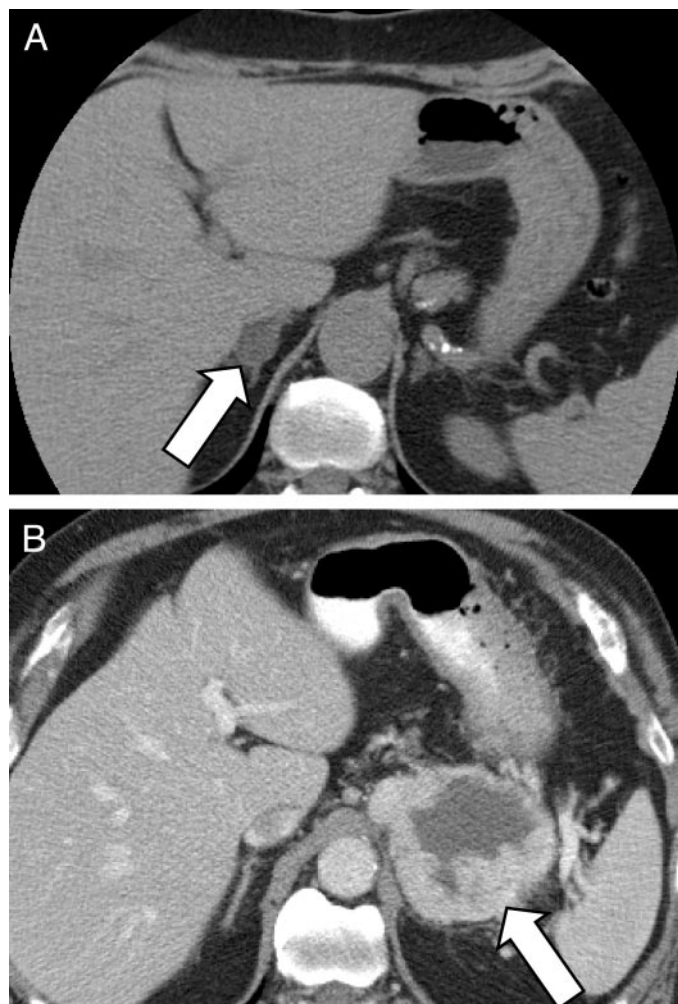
CT scans of the abdomen. A, Imaging characteristics of a typical adrenocortical adenoma (arrow). Imaging characteristics consistent with a benign cortical adenoma include round and homogeneous density, smooth contour and sharp margination, diameter usually less than 4 cm, unilateral location, low unenhanced CT attenuation values, and limited enhancement on CT with iv contrast. B, Imaging characteristics of a typical adrenal pheochromocytoma (arrow) include enhancement with iv contrast medium, cystic and hemorrhagic changes, and the possibility of bilateral tumors.
